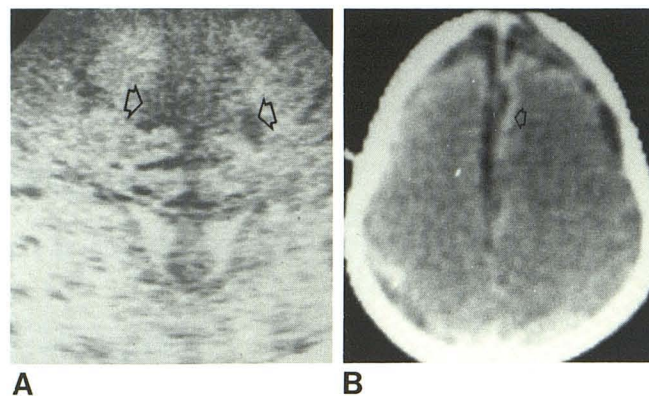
3-month-old infant with *H. influenzae* meningitis. A, Moderate ventricular enlargement and areas of increased echogenicity of cerebral cortex with accentuation of gray-white matter interface (arrows). B, Focal areas of contrast enhancement (arrow) correspond to areas of echogenicity on sonogram.
